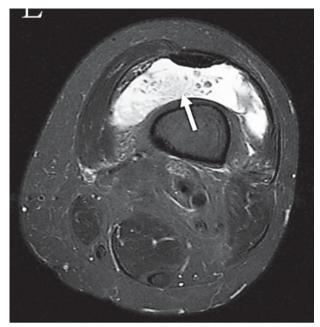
T2-weighted Magnetic Resonance Imaging scan shows a frond-like morphology of the synovial mass that is isointense relative to subcutaneous fat (white arrow).
